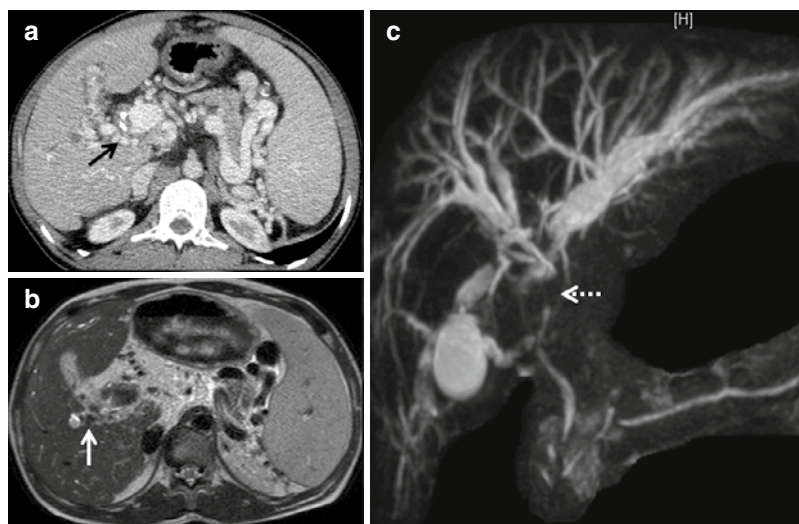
Portal cavernoma cholangiopathy. Contrast-enhanced CT (a) shows collaterals at the porta (black arrow in (a), replacing the main portal vein and around the gall bladder with portosystemic collaterals near the splenic hilum). These are seen as multiple signal voids
